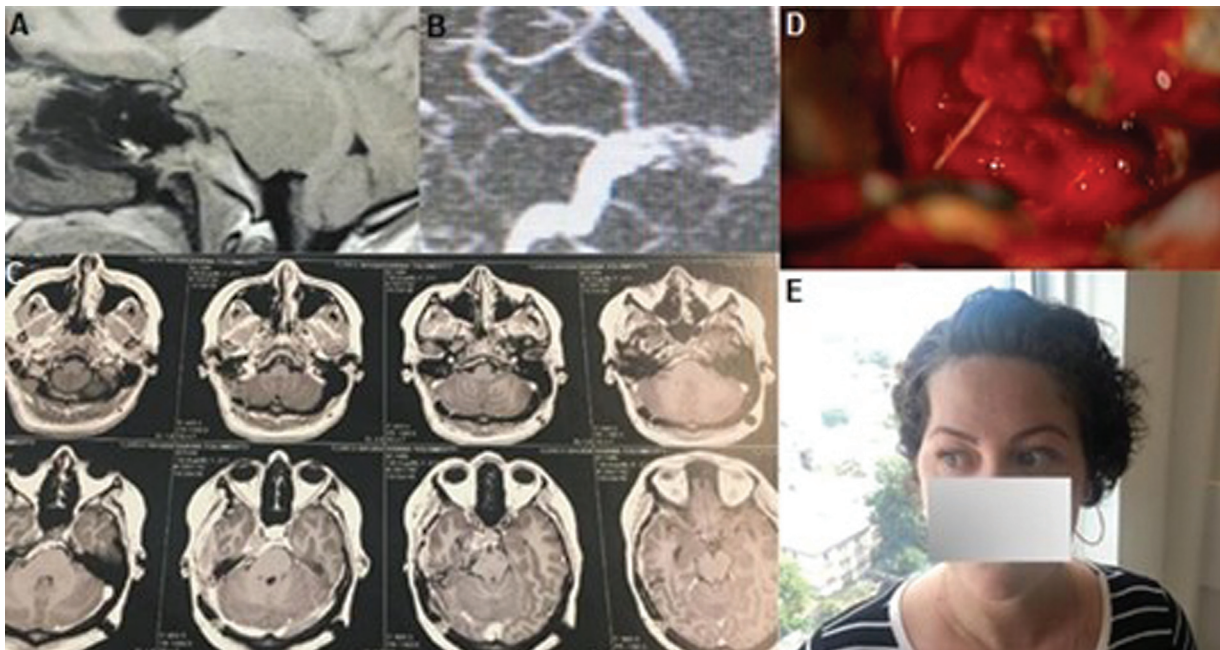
Sphenopetroclival meningioma. The patient had lower cranial nerves palsies and hemiparesis. (A) Sagittal T1-weighted image showing tumor interface with brainstem; (B) brain venography showing Labbé vein in its usual position. Based on that, a posterior petrosal approach was performed; (C) gadolinium enhanced T1-weighted postoperative image, showing near total resection; (D) intraoperative image showing the IV cranial nerve. Near total resection without ophtalmoparesis was achieved. Residual tumor left in the cavernous sinus; (E) asymptomatic patient in a 6-years follow-up. Annual magnetic resonance imaging (MRI) with no tumor growth.
